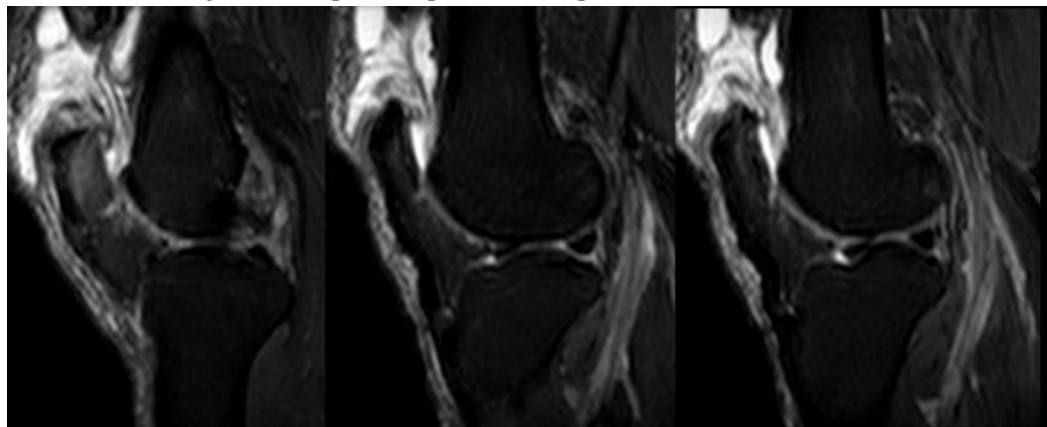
Pre-surgical x-ray quadriceps tendon rupture.
